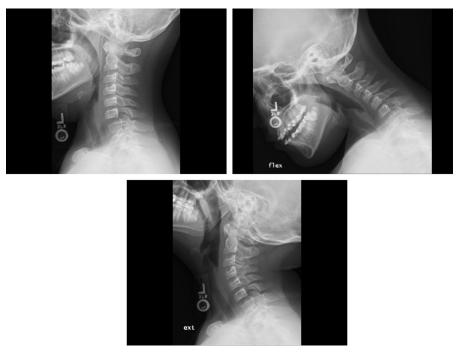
Plain radiographs of cervical spine (Top Left: lateral, Top Right: flexion, Bottom: extension).
